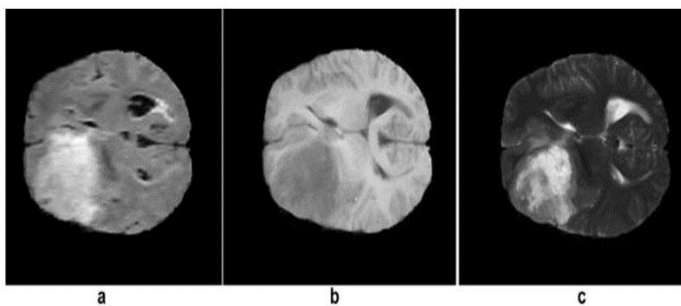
MRI brain tumor: (a) FLAIR image, (b) T1 image, and (c) T2 image
